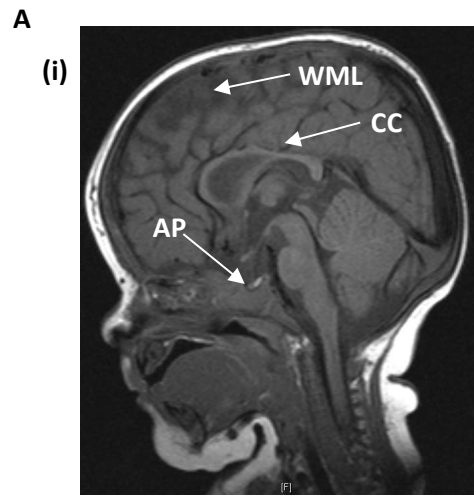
The MRI scans from the three affected males, IIIc, III d, IIIe. A-C: The patients have a small AP with an otherwise structurally normal pituitary gland, and a thin corpus callosum, indicated by the labelled white arrows respectively. A (i-ii) Sagittal images of patient IIIc showing generalised white matter loss, a small AP and a thin CC. A (iii) A coronal image of patient IIIc showing a small AP and ventricular asymmetry with the right ventricle being larger than the left. B (i) A sagittal image of patient III d showing generalised white matter loss, a small AP and a thin CC. B (ii) A coronal image of patient III d showing a small AP. C (i) A sagittal image of patient IIIe showing a small AP and a thin CC. C (ii) A coronal image of patient IIIe showing a small AP. CC, corpus callosum; AP, anterior pituitary; WML, white matter loss; VA, ventricular asymmetry.
